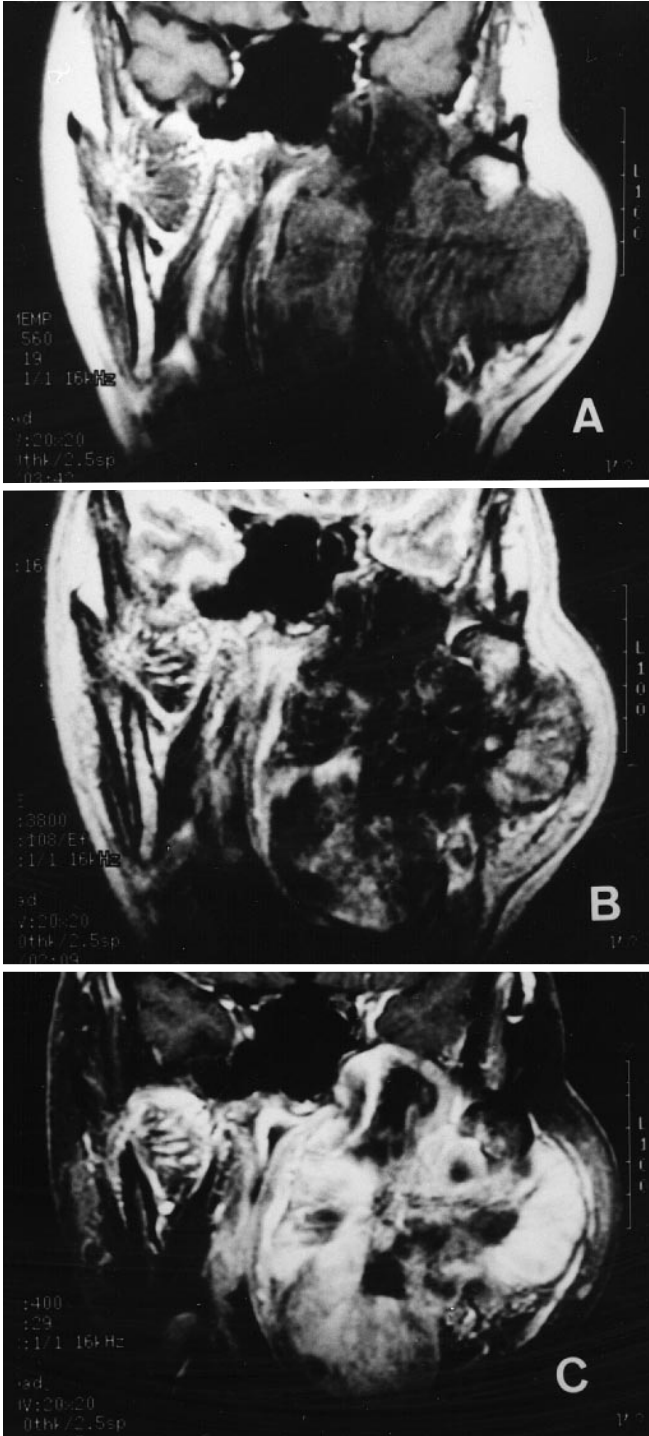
Coronal magnetic resonance imaging (MRI). A T1-weighted scans show a homogeneous low intensity tumor. B T2-weighted scans show the tumor with a heterogeneous low intensity. C Gadolinium-enhanced MRI. The tumor shows high heterogeneous enhancement
